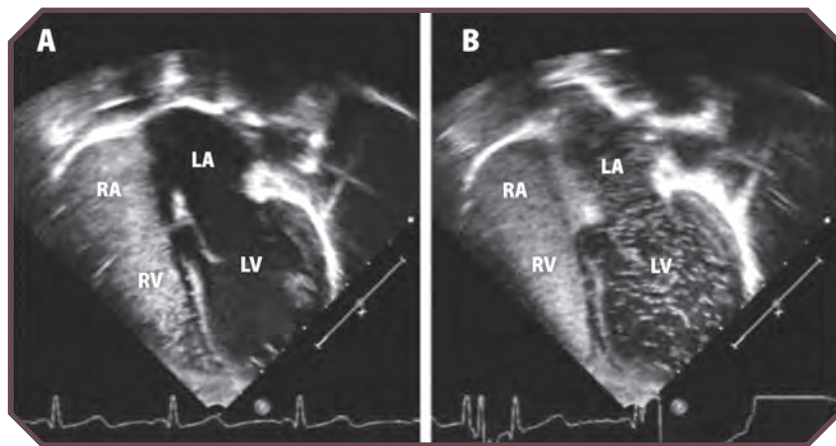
Contrast-enhanced echocardiography. An apical 4-window view was obtained after peripheral venous injection of agitated saline. A. Agitated saline is noticeable in the right atrium (RA) and right ventricle (RV). Note the absence of bubbles on the left side of the heart. B. After 3–4 cardiac cycles, agitated saline is now visible in the left atrium (LA) and left ventricle (LV). Findings are suggestive of intrapulmonary shunting. Images courtesy of Michael R. Carr, MD.
